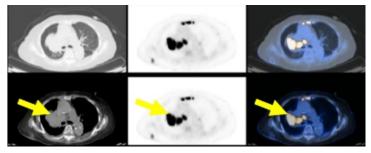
The right upper lobe bronchus is obstructed with resultant atelectasis of the right upper lung. Furthermore, the inferior border of the atelectasis appears lobulated with multiple foci of increased FDG activity (pointed by yellow arrow).
